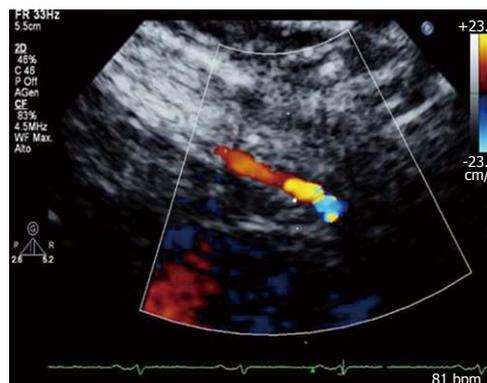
Color-Doppler signal in the distal left anterior descending coronary artery.
